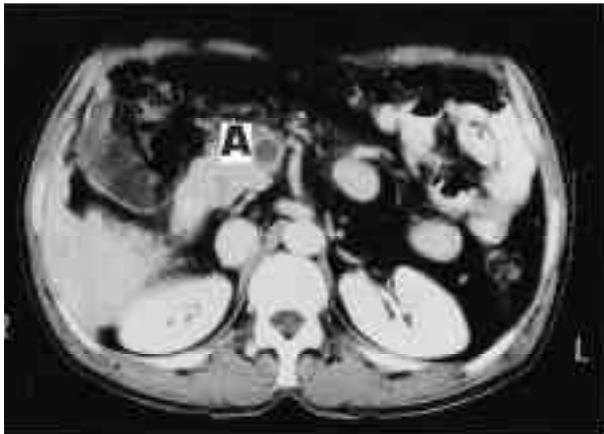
CT scan showing filling defect (a) In SMV.
